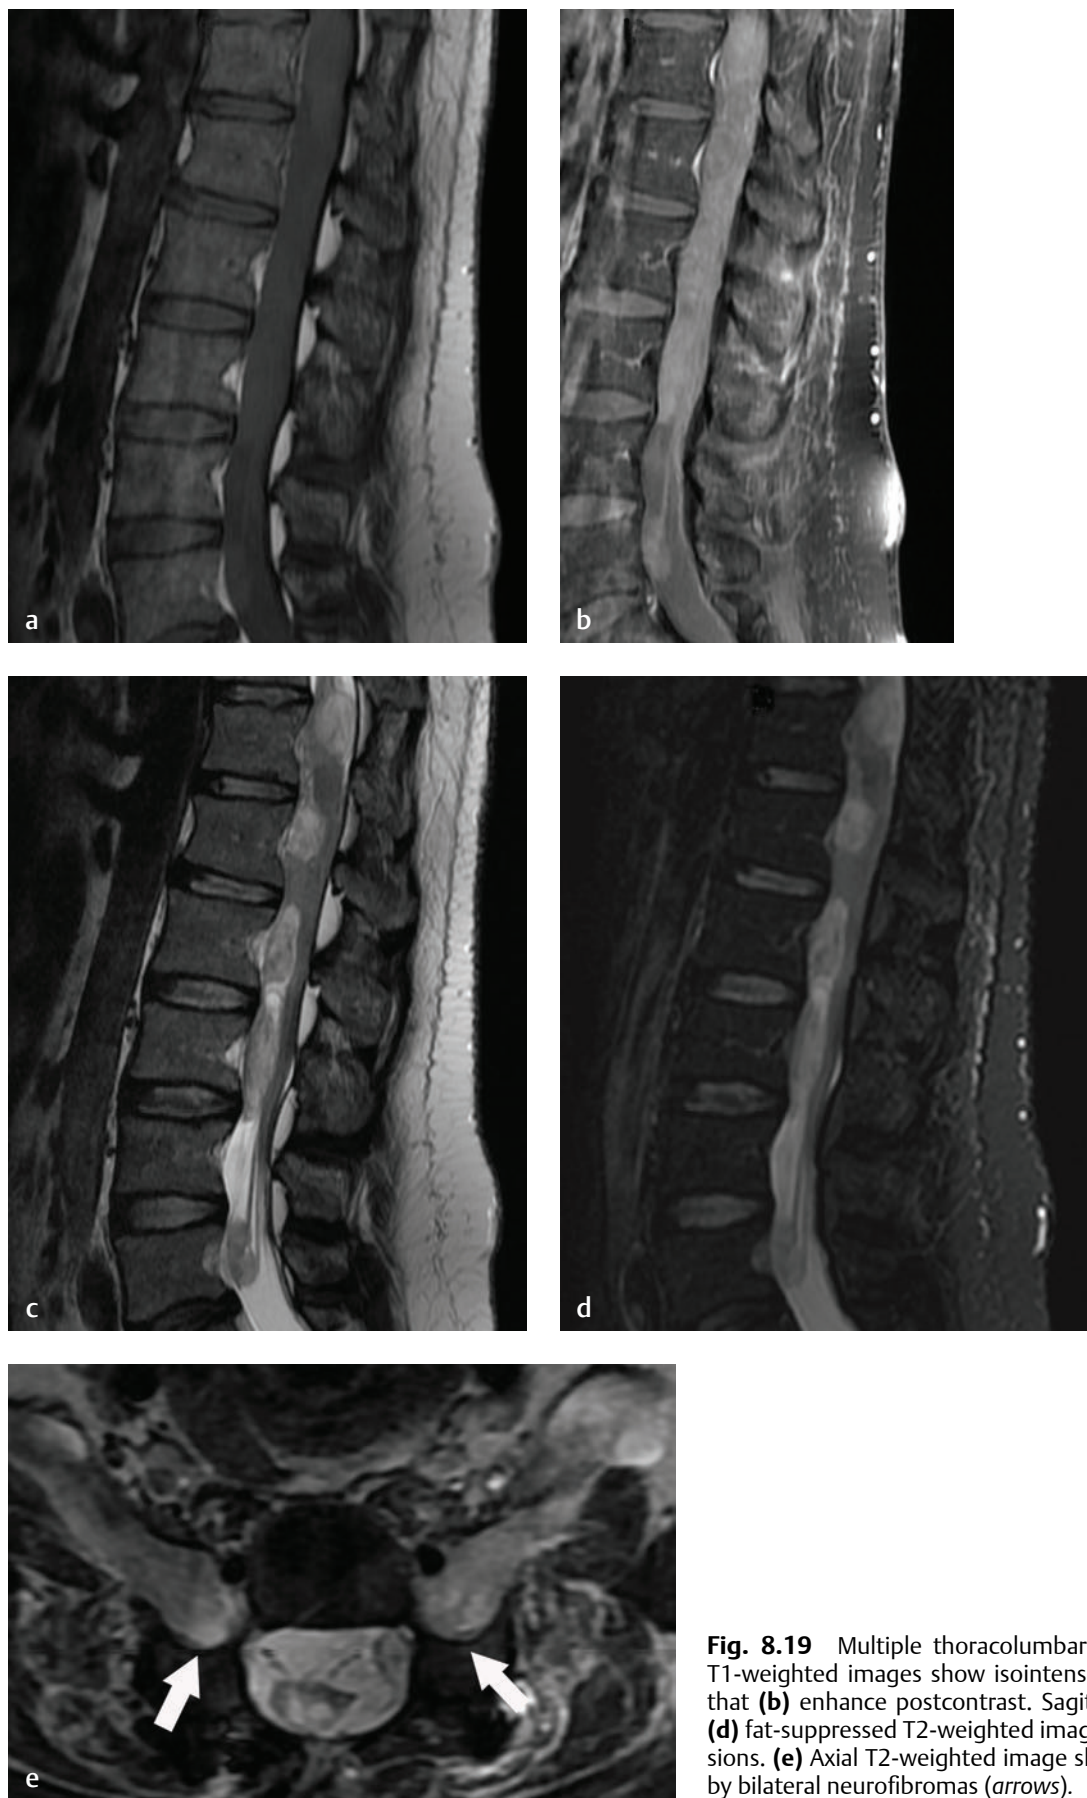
Multiple thoracolumbar neurofibromas. Sagittal T1-weighted images show isointense lesions (a) precontrast that (b) enhance postcontrast. Sagittal (c) T2-weighted and (d) fat-suppressed T2-weighted images show hyperintense lesions. (e) Axial T2-weighted image shows foraminal widening by bilateral neurofibromas (arrows).
